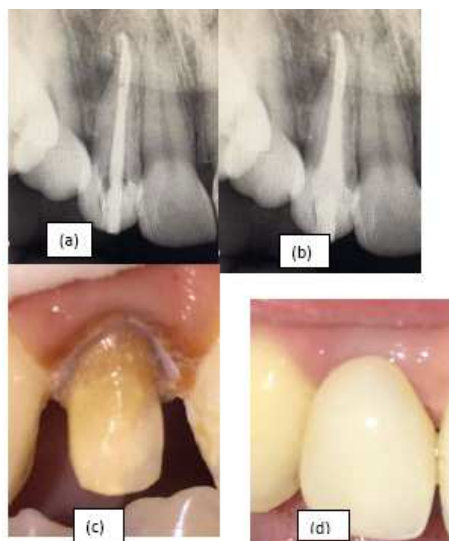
Radiographic and dental clinical images of the tooth 12. (a) Post experiment, (b) stake cementation with breeze, (c) clinical core photo, (d) dowel crown
